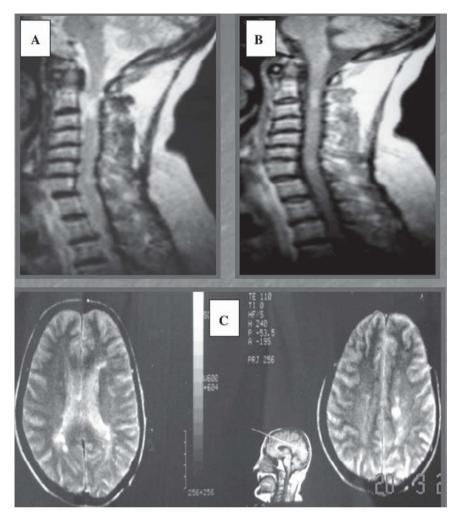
A. Sagittal image of the T2-weighted MRI study of the spine: cervical arthrosis and a hyperintense area in the spine at the C2 level can be seen. B. Sagittal image of the T2-weighted MRI study performed 4 years later: new hyperintense areas are sen in the cervical spinal cord. C.Axial image of the T2-weighted MRI brain study: multiple hyperintensities in the periventricular white matter and semioval centres.
